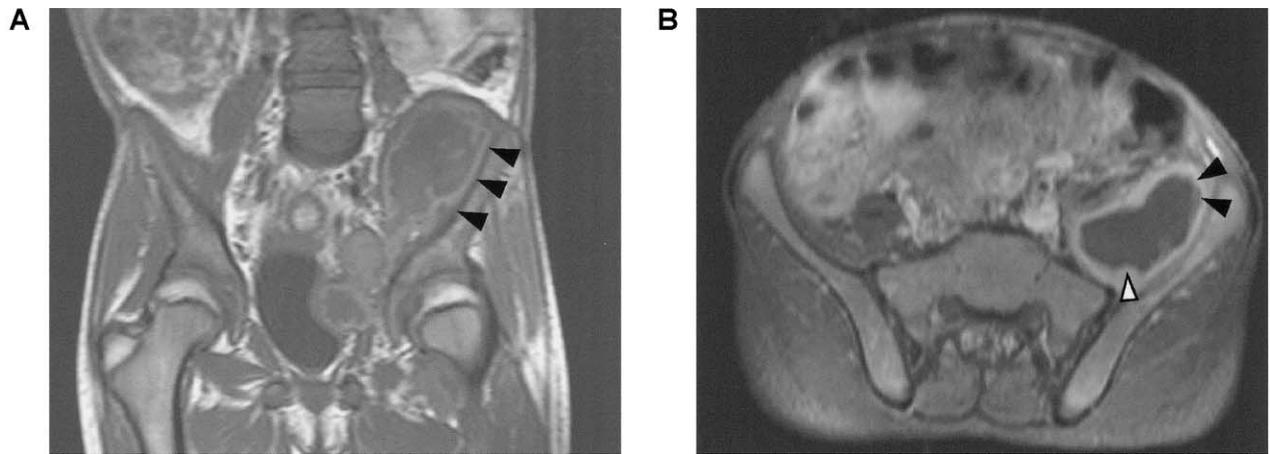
Frontal (A) and horizontal (B) views of MRI of the abdomen showing a large abscess (black arrow) with a thick wall (white arrow) and septum in close contact with the left hemipelvis.
